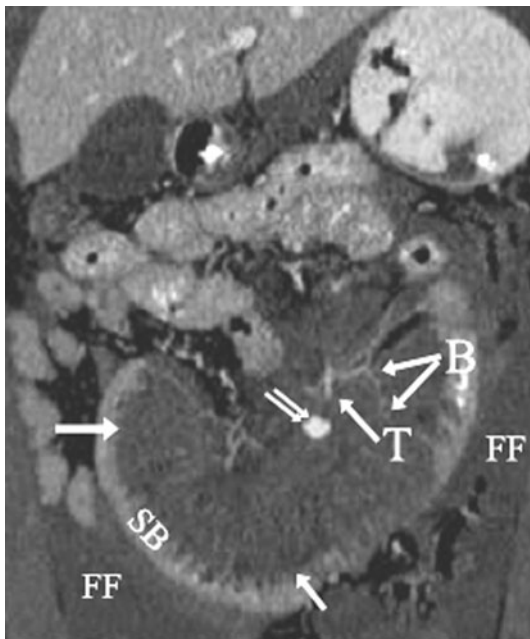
A 24-year-old male status post-blunt abdominal trauma. Coronal reformatted CT image of the abdomen with intravenous contrast material demonstrated abrupt termination (*T*) and beading (*B*) of jejunal branches of the superior mesenteric artery. A large hematoma in the mesentery (*arrows*) with active bleeding (*double arrows*) was noted and was surrounded by a loop of small bowel (*SB*). Diffuse free fluid (*FF*) in the abdomen was noted. At surgery, a large mesenteric hematoma with active bleeding and perforation of jejunum were found.
